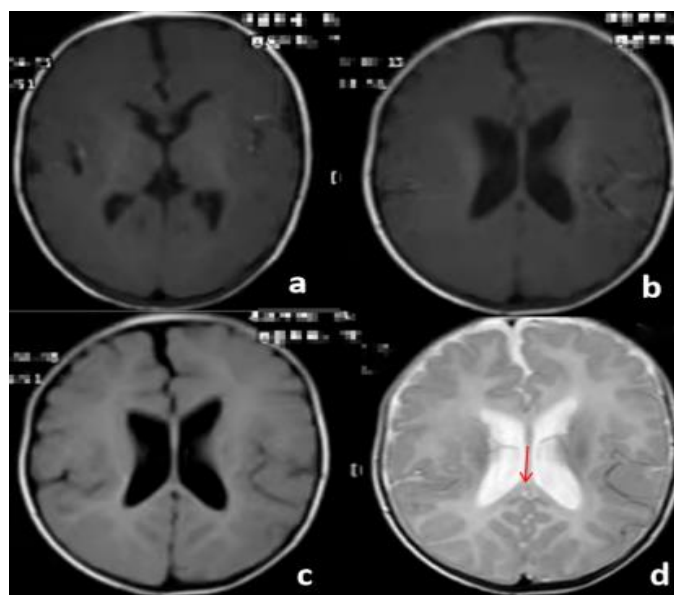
Brain MRI showing dysplasia of the corpus callosum and dilation of the bilateral ventricles (a-d).
